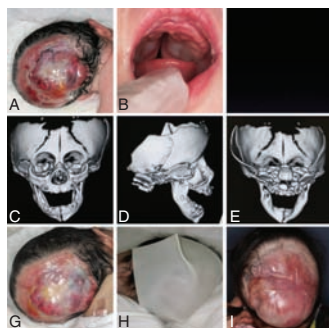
(A) Presentation at 4 days. Large scalp and skull defects and (B) hard and soft cleft palate. (C) AP view of three-dimensional computed tomography of the skull defect, including frontal, parietal, and temporal bones, (D) lateral view, (E) PA view. (F) Treatment using a patch of lyophilized dura mater to manage leakage of cerebrospinal fluid. (G) The scalp defect covered with Mepilex Transfer. (H) On day 212, epithelialization was achieved.
